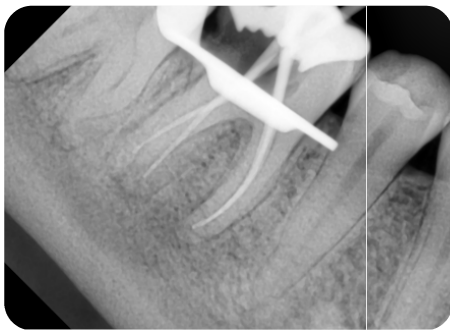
Martercone radiograph
